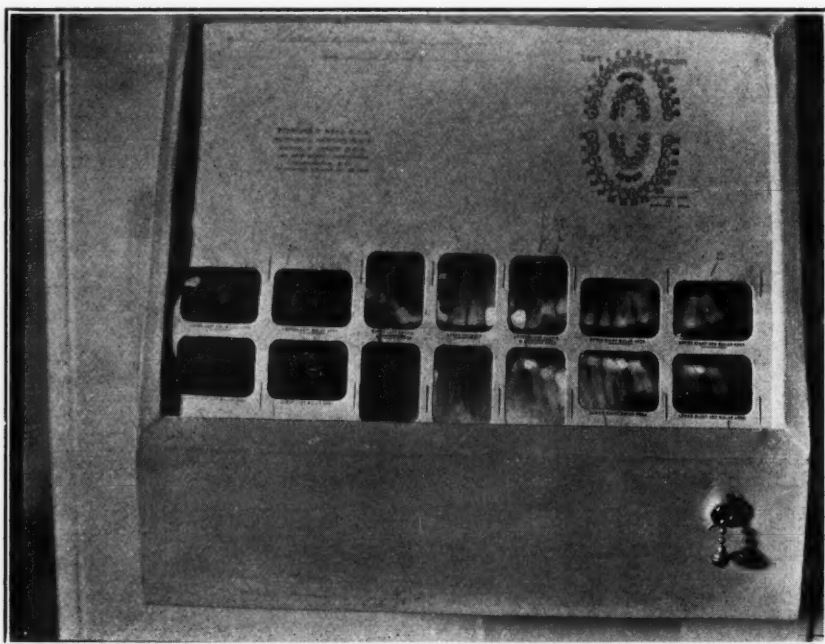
Wall illuminating box for roentgenograms.
